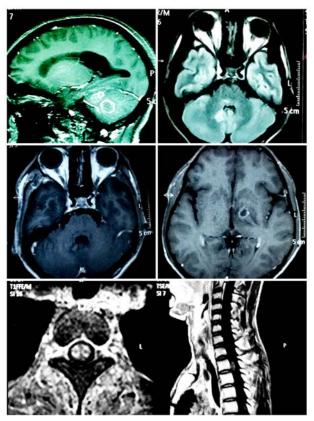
Contrast MRI of brain shows multiple conglomerate ring enhancing lesion (First to four )MRI Cervical spine axial/saggital section shows ring enhancing lesion
